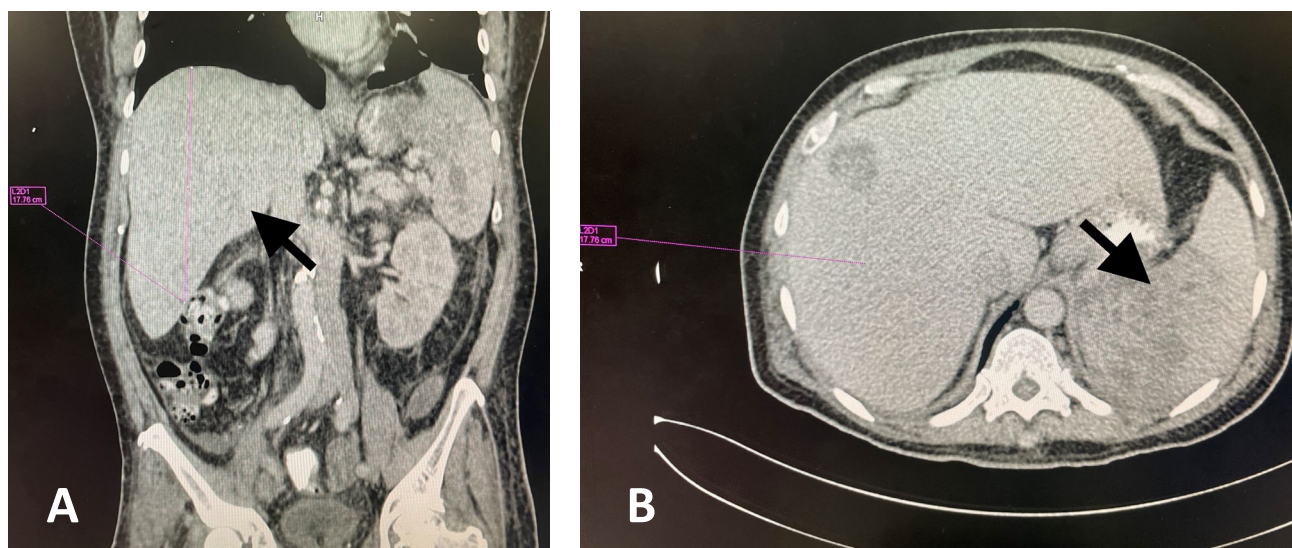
Whole abdomen computed tomography scan with oral, rectal, and intravenous contrast showing hepatomegaly (A) and splenomegaly (B).
